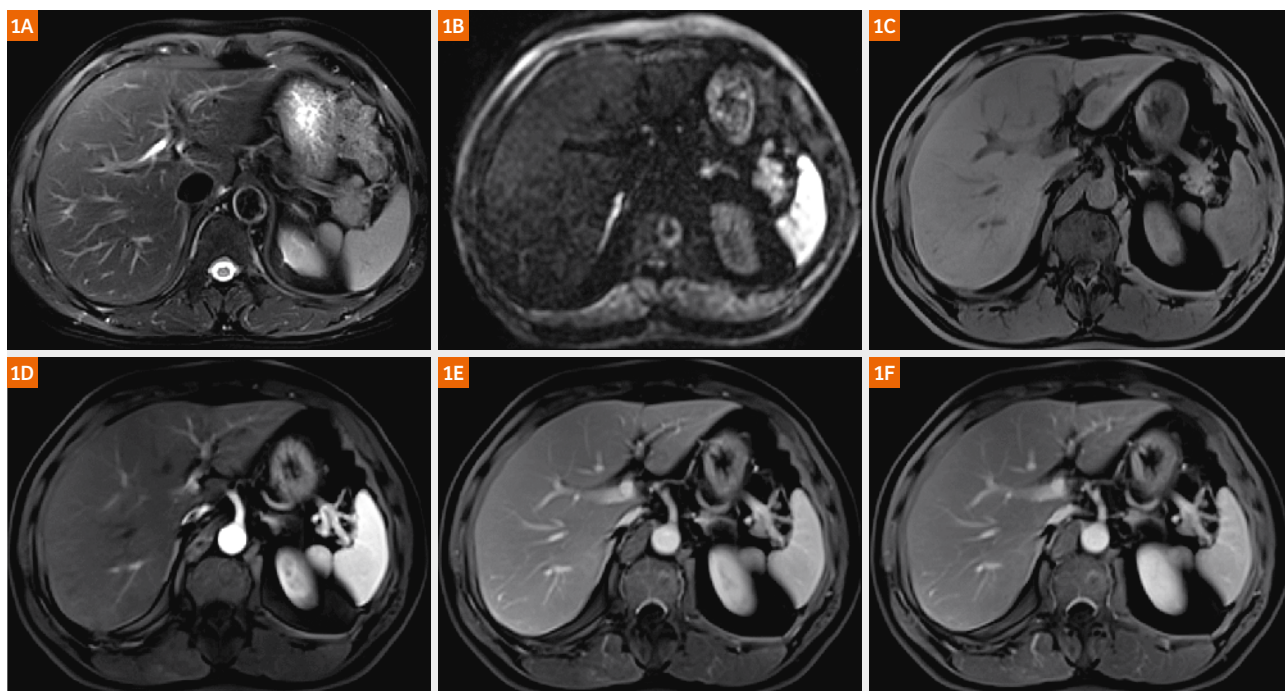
Images of a healthy 53-year-old man: (1A) T2-weighted BLADE; (1B) DWI, $b = 1000 \text{ s/mm}^2$; (1C) pre-contrast T1w; (1D) arterial phase T1w; (1E) venous phase T1w; (1F) delayed phase T1w. The images show that the automated fast protocol achieves satisfactory image quality and anatomic structure visualization.
